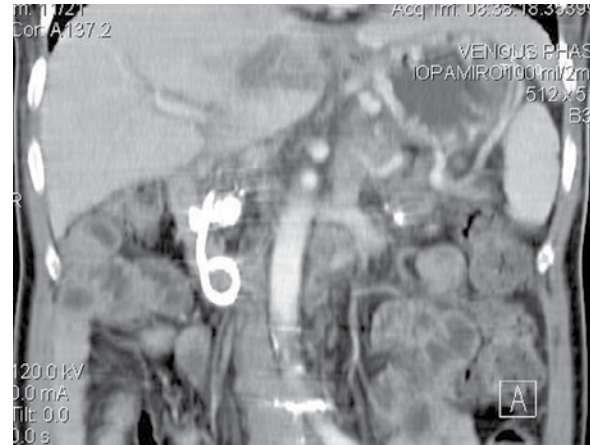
A coronal view of CT scan demonstrated a plastic stent was placed along common bile duct. It ran across calcification in the head of pancreas.
